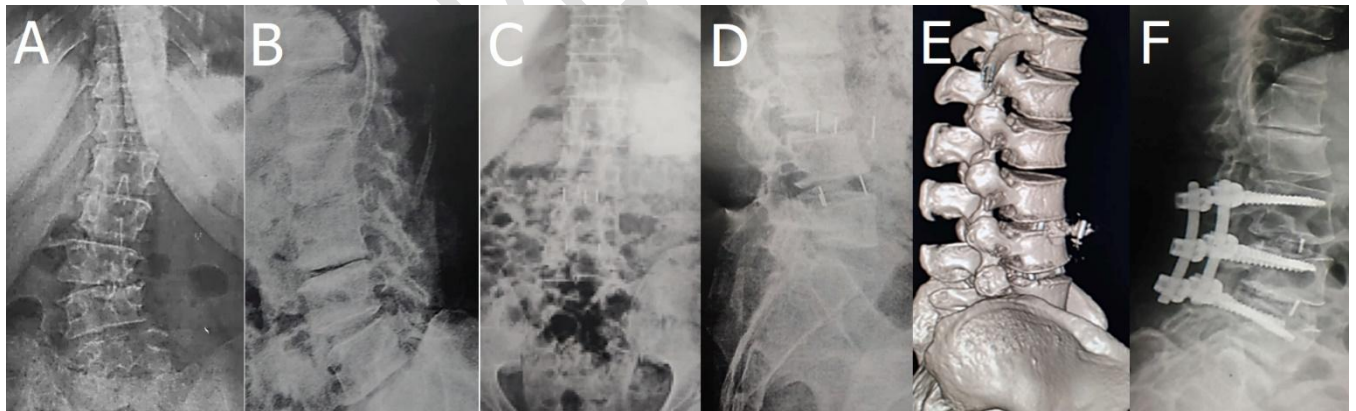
Case 4; a 31 year old male patient complaining of back pain and leg pain of 24 months duration A: AP X-ray L/S spine with Degenerative scoliosis L3/L4 and L4/L5 and *Cobb angle* was 21 degrees B: Lat. X-ray L/S spine with lumbar spine decreased lordosis and degenerative pattern in L3/L4 disc and *LL* was 10 C: AP X-ray L/S after first session shows improved *Cobb angle* to 4 degrees, D: Lat. X-ray L/S spine shows L3/L4 cage dislodgment and stable L4/L5 cage, E: CT 3D reconstruction, and F: Lat. X-ray L/S spine shows posterior instrumentation and cage re-application anteriorly.
